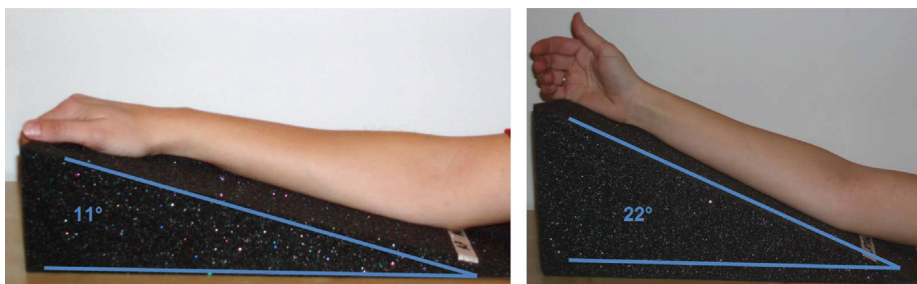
Placement of the supports for radiographic projections.
